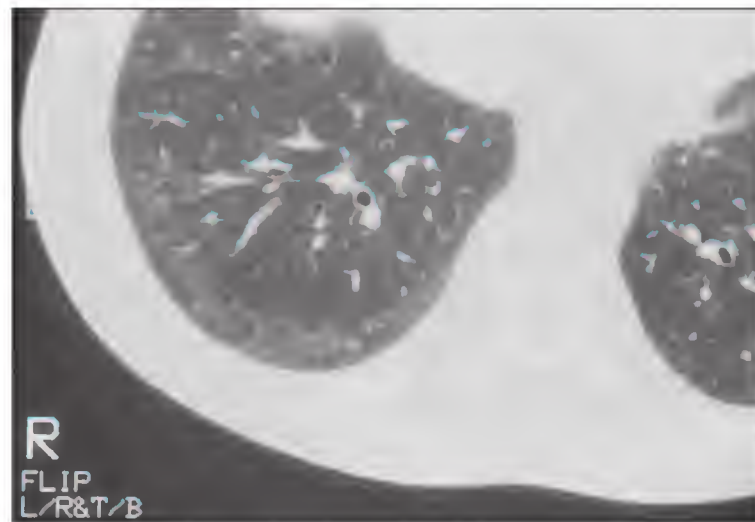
High-resolution computed tomographic scan of the chest of a patient with systemic sclerosis and alveolitis demonstrating ground-glass opacification, a haziness visualized at the lung periphery.
